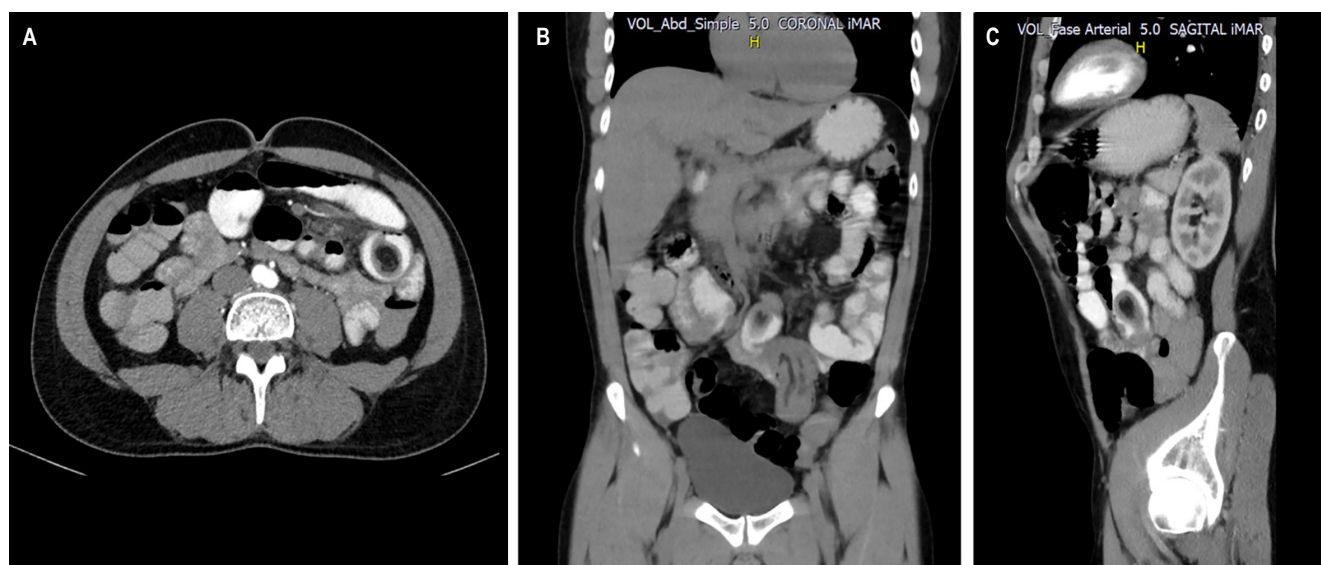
Axial (A), coronal (B), and sagittal (C) views of an abdominal and pelvic computed tomography scan with oral and intravenous contrast. The images show a target or doughnut sign in the region of the ileal loops, suggestive of intussusception. Images provided by the Ubiqno System, Hospital Universitario San José, Popayán, Colombia.
